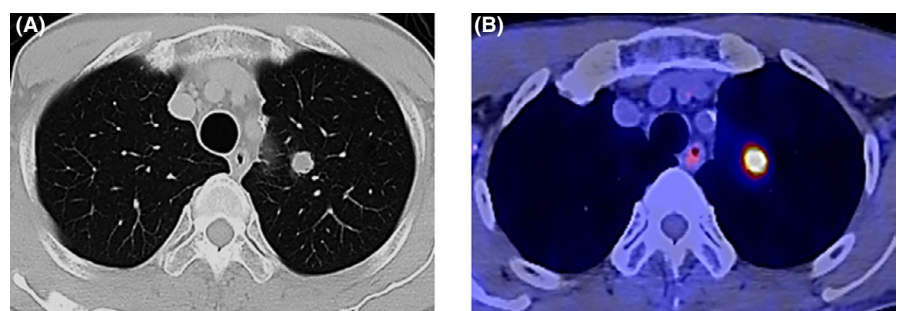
A lung metastatic lesion detected through computed tomography (A) and positron emission tomography (B)
